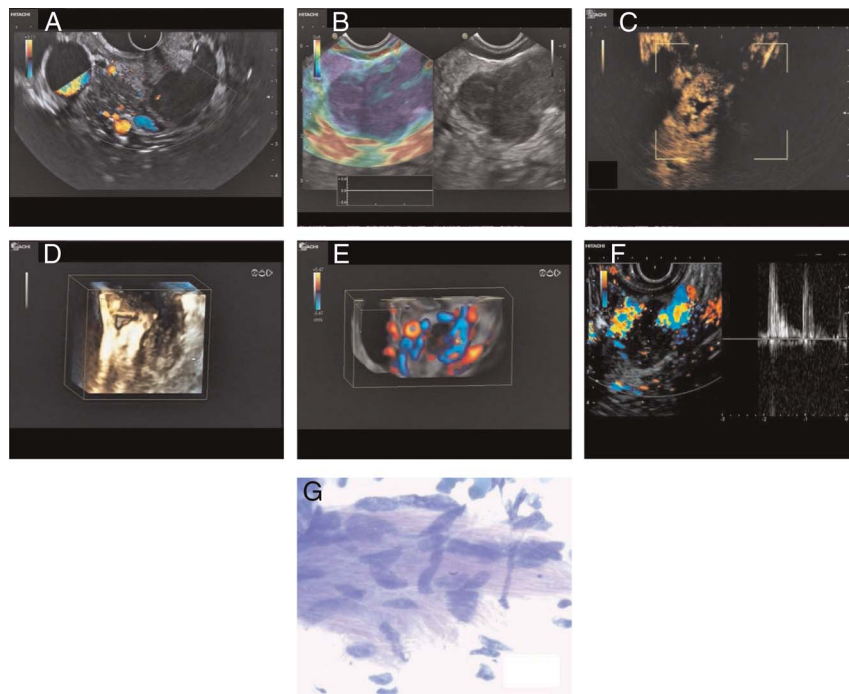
Extragastrointestinal stromal tumor at the pancreatic head. Display of the GIST tumor on the right side and the normal pancreatic head on the left side. The scan was taken from the descending duodenum. Unenhanced Doppler color display is overlaying the gray scale scan (A). The hypoechoic tumor is visible with the result of the elastographic scanning on the left side. The tumor appears blue that means harder than the surrounding tissue (B). Contrast-enhanced harmonic EUS with 4,8 mL SonoVue. The typical highly vascularized tumor and the central necrosis are visible (C). The tumor is displayed using 3D reconstruction after injection of 4,8 mL SonoVue in CEH-EUS (D). The same tumor in a 3D reconstruction of a color Doppler mode overlaying gray-scale ultrasound. The surrounding vessels are clearly visible (E). Pulsed-Wave (PW)-Doppler mode after injecting of 4.8 mL SonoVue in high-mechanical-index EUS, only high-resistance arterial vessels can be detected within the tumor (F). Cytological result after endosonographic fine-needle puncture of the tumor. Typical mesenchymal tumor cells are displayed (H).
